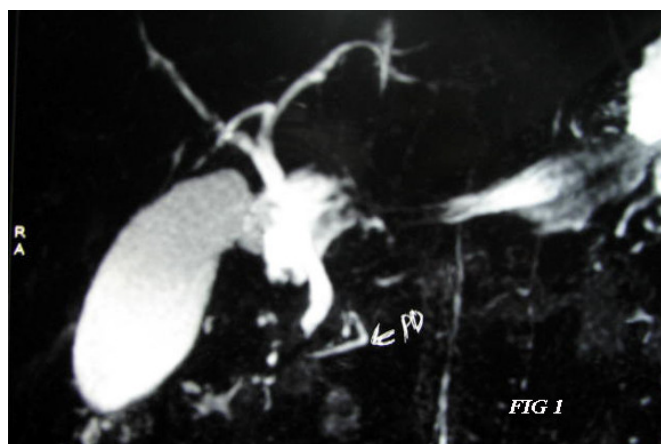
MRI showing small pancreatic duct
